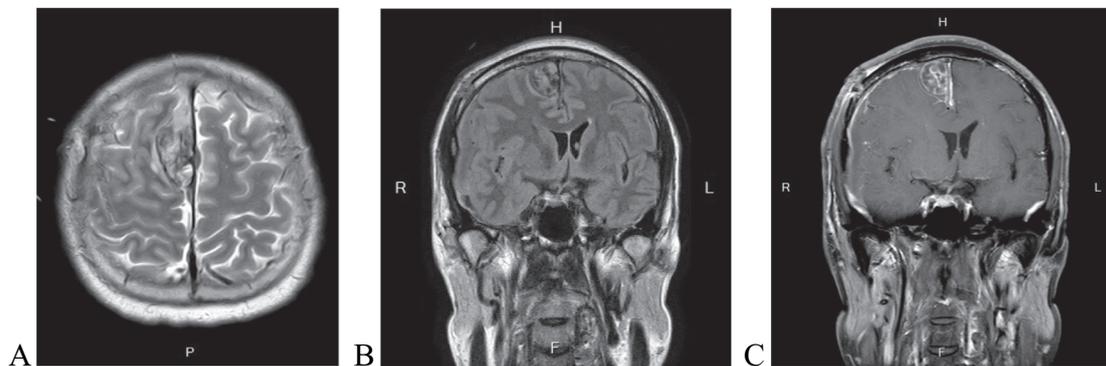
Brain MRI. A) Axial view of T2 weighted image. B, C) Coronal view of T1 weighted image and T1 enhanced image.
